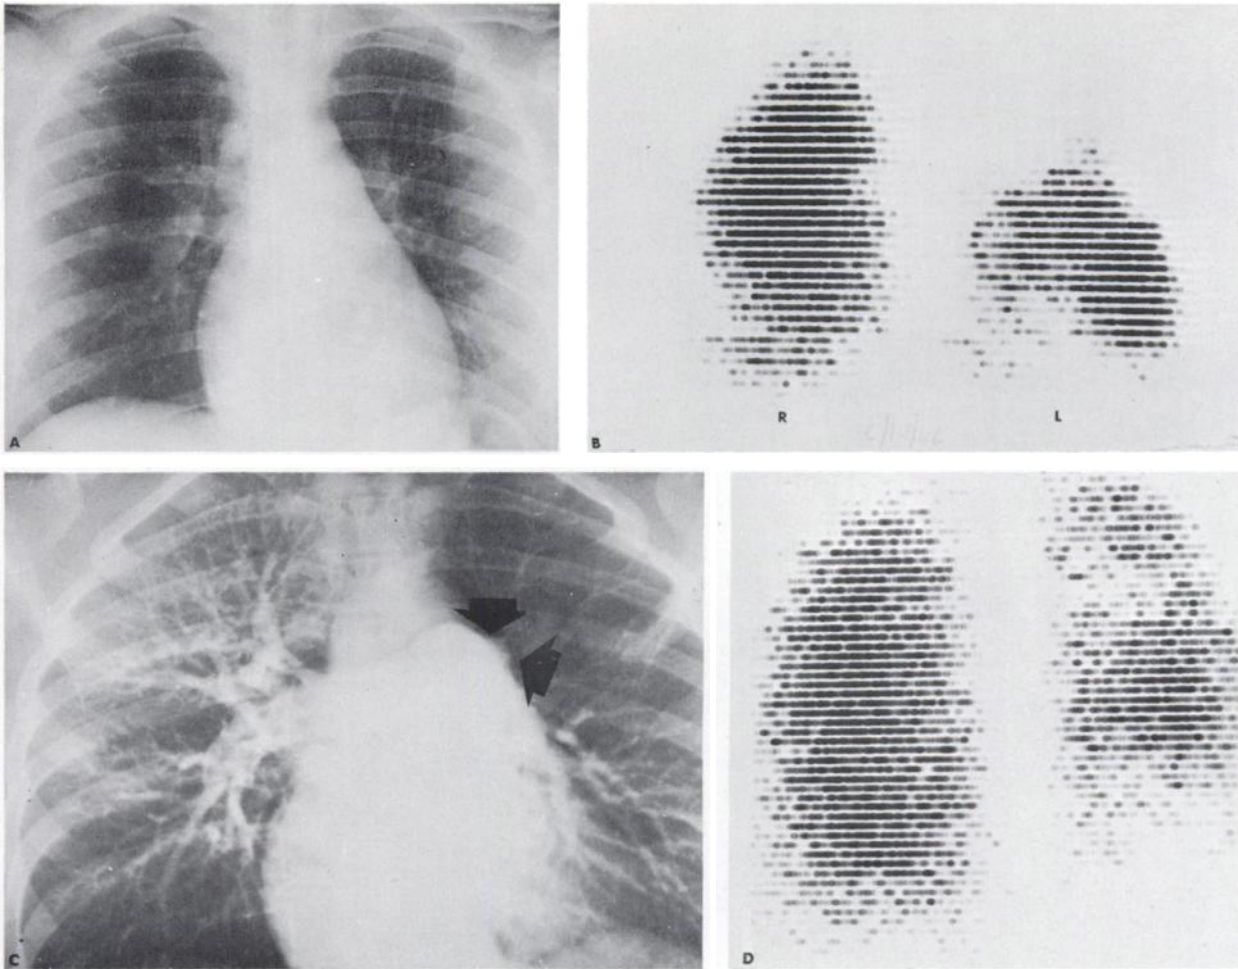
Case 1. Left upper-lobe embolus in 29-year-old female. A: Chest roentgenogram is unremarkable. B: Posterior lung scan reveals large perfusion defect in left upper lobe. There is also some patchiness of activity at right base with motion artifact also present. C: Pulmonary angiogram demonstrates complete occlusion of left upper-lobe pulmonary artery (arrows) with relative avascularity of left upper lobe. D: Repeat posterior lung scan 6 weeks later shows a moderate return of left upper-lobe activity. Some generalized diminution of left lung activity is seen at this time. Right base has relatively normal perfusion.
